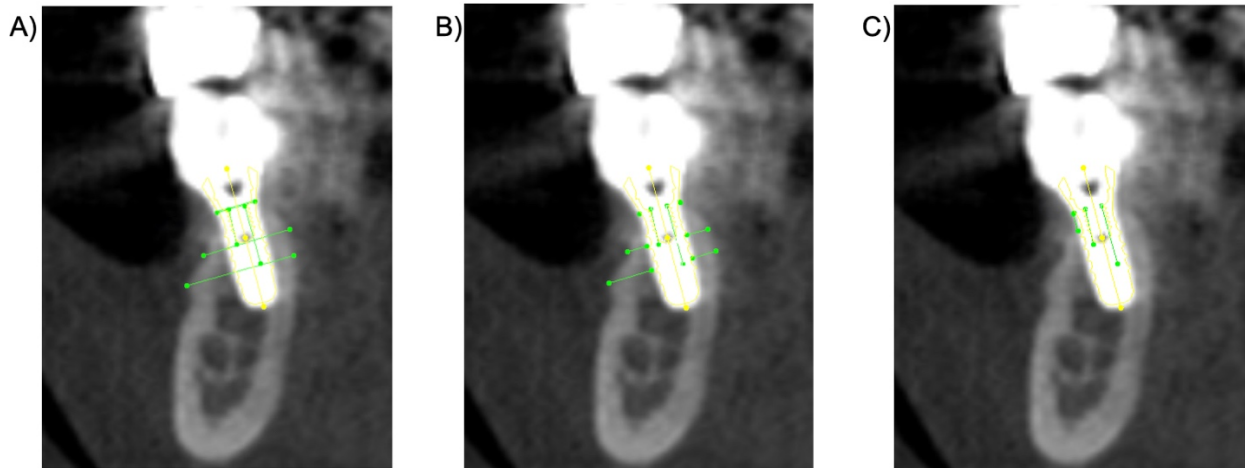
CBCT measurements. A) width of the healed ridge (WR), measured at 0, 3 and 5mm below the SLA border; B) thickness of the buccal bone and lingual/palatal bone, measured at 0, 3 and 5mm below the SLA border; C) the distance between the SLA border to the bone crest (BC;SLA-BC).
